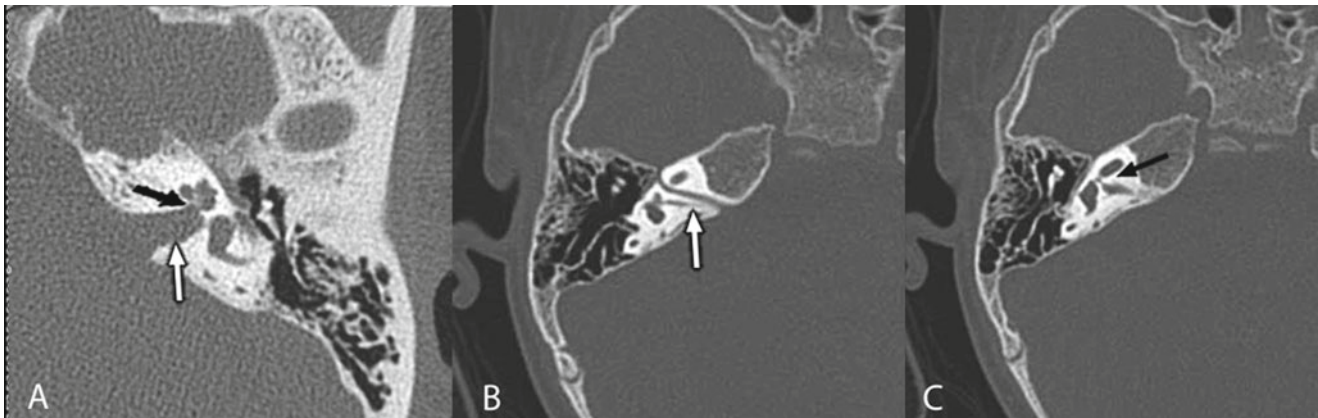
Axial section high-resolution CT of the temporal bones demonstrating (a) left ear with internal auditory canal (IAC) of normal caliber (white arrow) and patent bony cochlear nerve canal (BCNC) (black arrow); right ear with (b) narrow IAC (white arrow); and (c) absent BCNC (black arrow)
